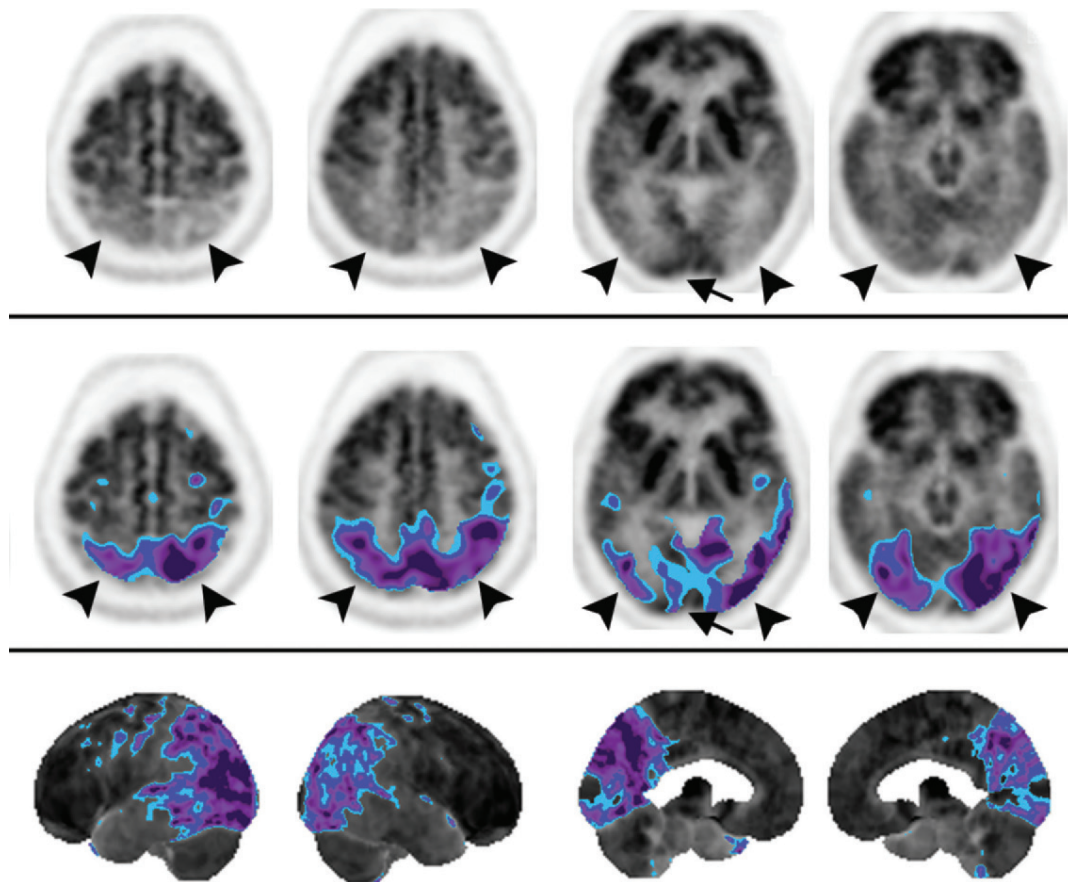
PCA. Axial gray-scale FDG PET images (top), corresponding statistical thresholding overlay images (middle), and 3D SSP images (bottom) (left to right: left lateral, right lateral, left medial, and right medial views) show posterior parietotemporal and occipital hypometabolism (arrowheads). An atypical variant of Alzheimer disease, PCA is characterized by a posterior cortical hypometabolic pattern of Alzheimer disease but with additional involvement of the lateral occipital association cortices (arrows). Blue = -2 SDs, purple = -3 SDs. Patients with PCA show a progressive, dramatic, and relatively selective decline in visual association skills.
